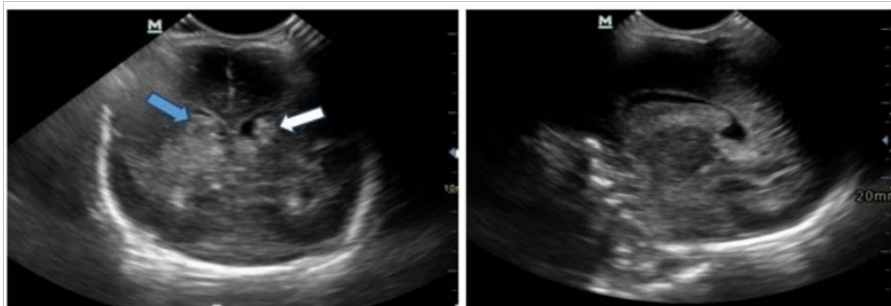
Cranial ultrasound done on 19th day of life showing bilateral persistent Intraventricular Haemorrhage with periventricular cystic changes (white arrows)
